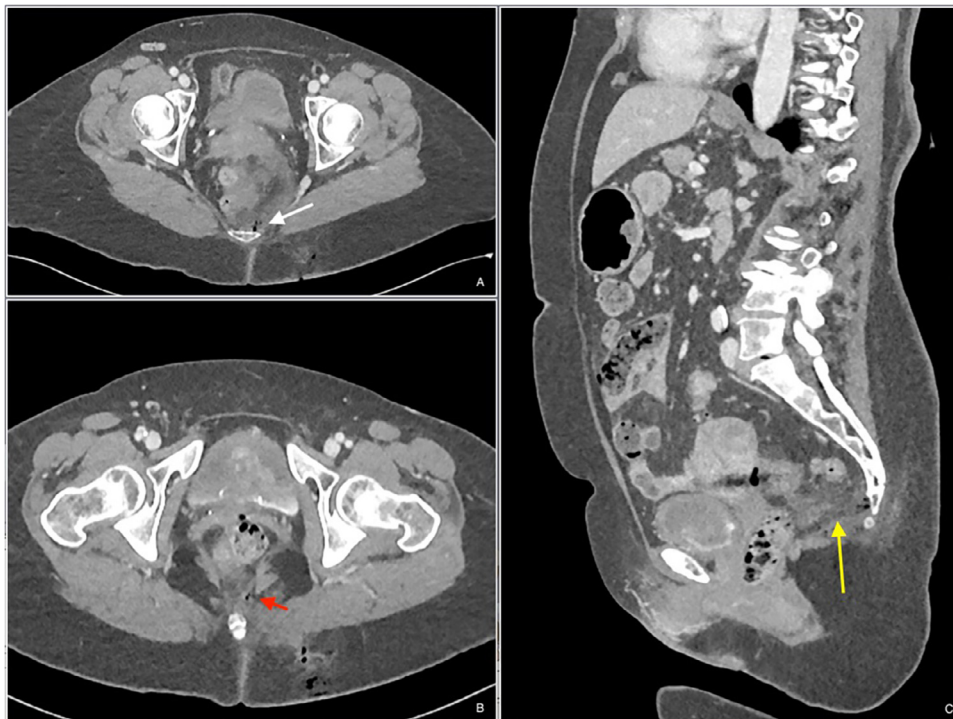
(A-C). Axial CT images (parenchymal phase). The air within the entry wound extended into the retroperitoneum in presacral space (A) (white arrow) and at level the lateral border of the levator ani muscle (B) (red arrow). Perirectal fat stranding was appreciable (yellow arrow). CT findings were suggestive of extraperitoneal rectal perforation.
